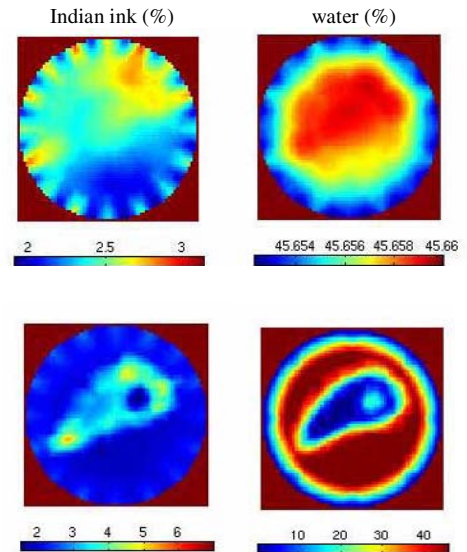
Reconstructed water and Indian ink concentrations obtained from DOT without a-priori information from MRI (top row), with structural and functional-prior from MRI (bottom row).
